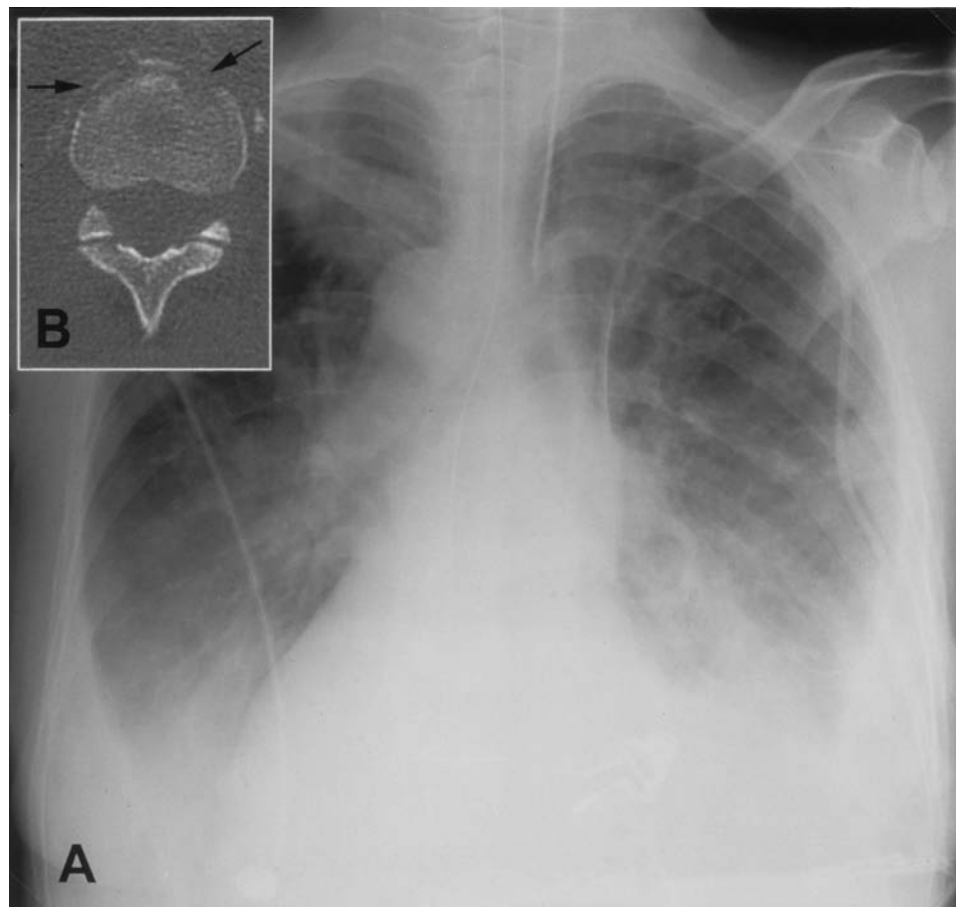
A, Conventional radiograph of the thorax showing bilateral pneumonia and pleural effusion. B, CT scan of the T12 vertebra showing erosions caused by spondylitis (arrows) and severe decalcification caused by osteoporosis.
